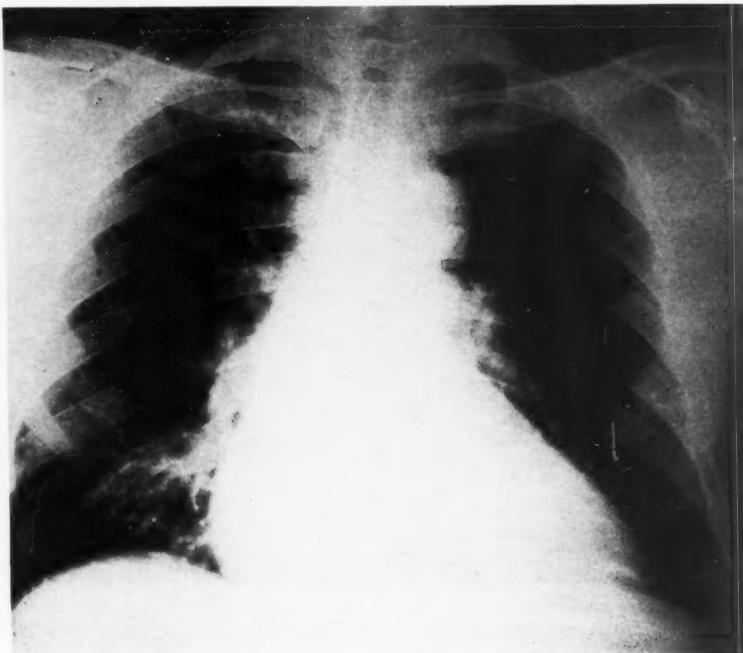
Roentgenogram showing considerable enlargement of the heart. Note minimal pulmonary congestion.
